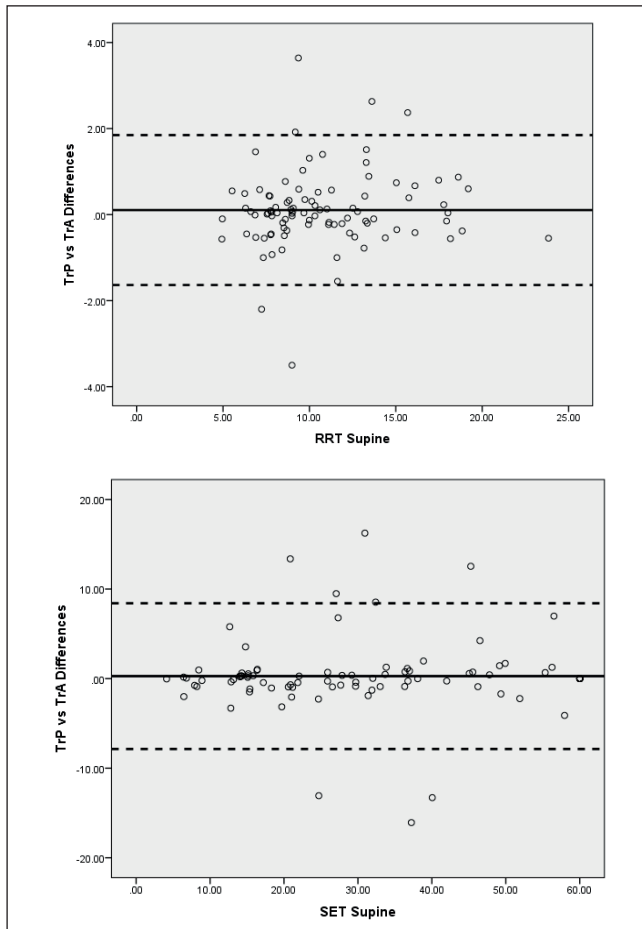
Bland-Altman plots presenting the limits of agreement for two assessors measuring the same patients on the rapid response test (RRT) in the upper panel, and the sustained endurance test (SET) in the lower panel — all tests were conducted using transabdominal real-time ultrasound images with patients in the supine posture.
